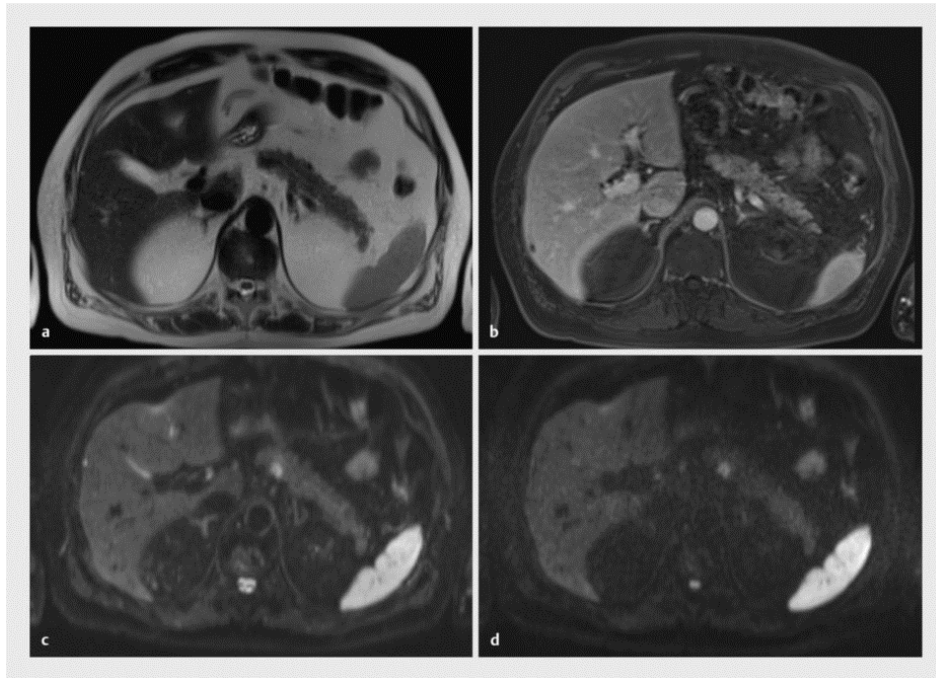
76-year-old female patient with elevated CA 19-9, CT scan of the upper abdomen was unremarkable, as was endosonography.
